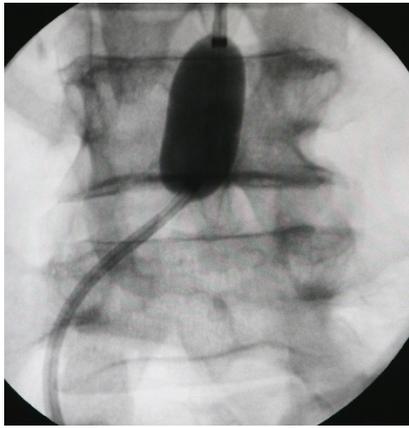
An X-Ray image of an inflated balloon placing at L3 vertebral level.
